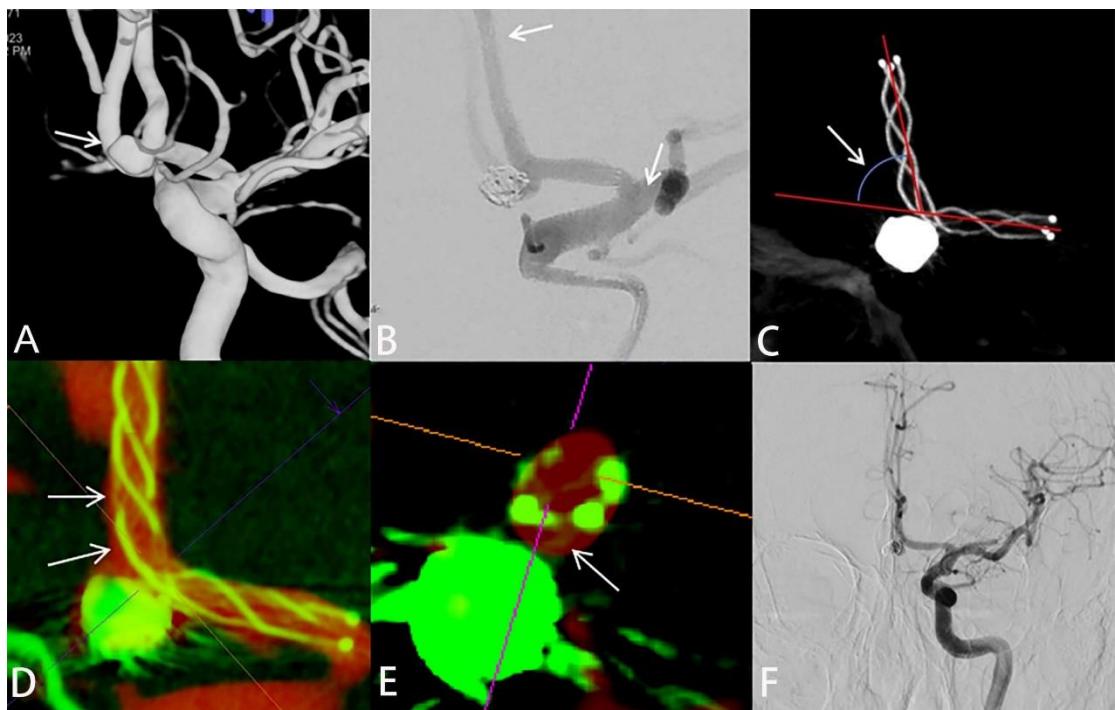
Use of a LVIS Jr stent in SAC for the treatment of an unruptured anterior communicating artery aneurysm. A. 3D-DSA suggests an aneurysm of an anterior communicating artery, with a saccular shape and size of $2.3 \text{ mm} \times 2.8 \text{ mm}$. The parent-artery diameter is 1.87 mm, and the diameter ratio is 1.15 (aneurysm is shown by a white arrow). B. SAC using a LVIS Jr stent ($2.5 \text{ mm} \times 23 \text{ mm}$) was undertaken, and the aneurysm occlusion density was Raymond–Roy class I (white arrow indicates the end of the stent). C. HR-CBCT shows that the stent was completely deployed and that the angle of stenting was 68.63° . D–E. These images were obtained by the dual-volume fusion reconstruction method. A type-II “crescent” incomplete stent apposition at the greater curvature of the stent at the aneurysm neck can be observed in sagittal and transverse planes. (white arrow shows incomplete apposition in the endovascular lumen). F. DSA follow-up at 6 months shows the coils in the aneurysm to be compressed, and the aneurysm has recurred.
